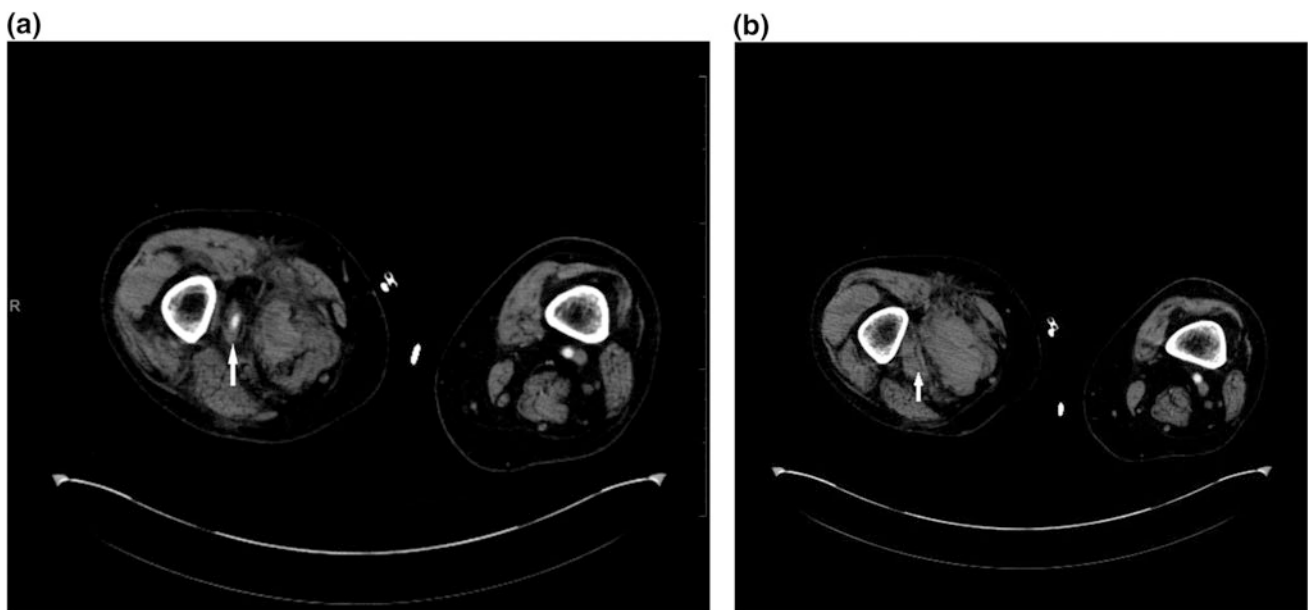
CT angiogram of a patient with popliteal artery injury with pseudoaneurysm [(a) white arrow], contrast extravasation, and inability to identify artery on distal images [(b) white arrow]
